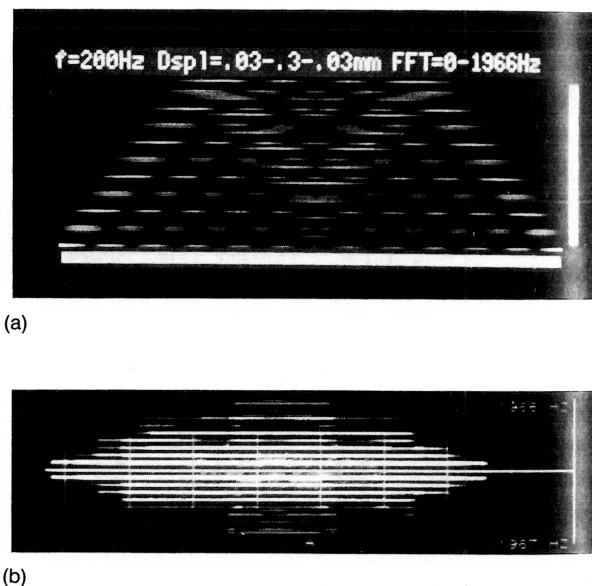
Time-frequency display of the Doppler shift from 200 Hz vibration over a range of displacement amplitudes. Theoretical results are shown in (a) where the vertical scale is Doppler shift from 0 to 1966 Hz, and the horizontal scale represents different displacement amplitudes from 0.03 mm (left) to 0.3 mm (center) to 0.03 mm (right). In these cases the FM modulation parameter, β , varies from approximately 2 left to 19 center. In (b), experimental results from the Quantum QAD1 in Spectrum mode are given from a region of interest near a 200 Hz vibration source at "A," while the amplitude is varied from low to high to low (left to right on time-frequency display at bottom). The vertical spectral scale is -1967 to +1966 Hz Doppler shift.
